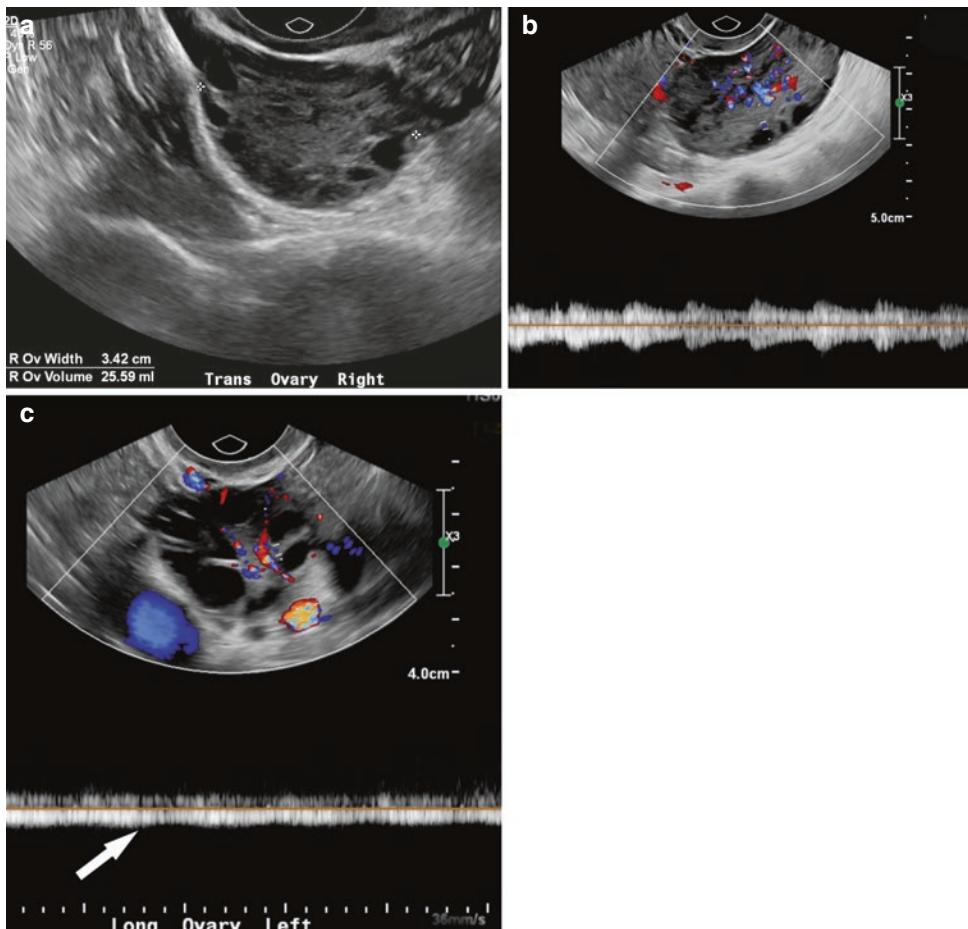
(a) Transvaginal US image of a 26-year-old woman with a 3-day history of right pelvic pain. Ovarian torsion was found in the OR. The right ovary is enlarged with a volume of 25 cc with peripherally located follicles. (b) Pulsed Doppler sagittal image through the same ovary
